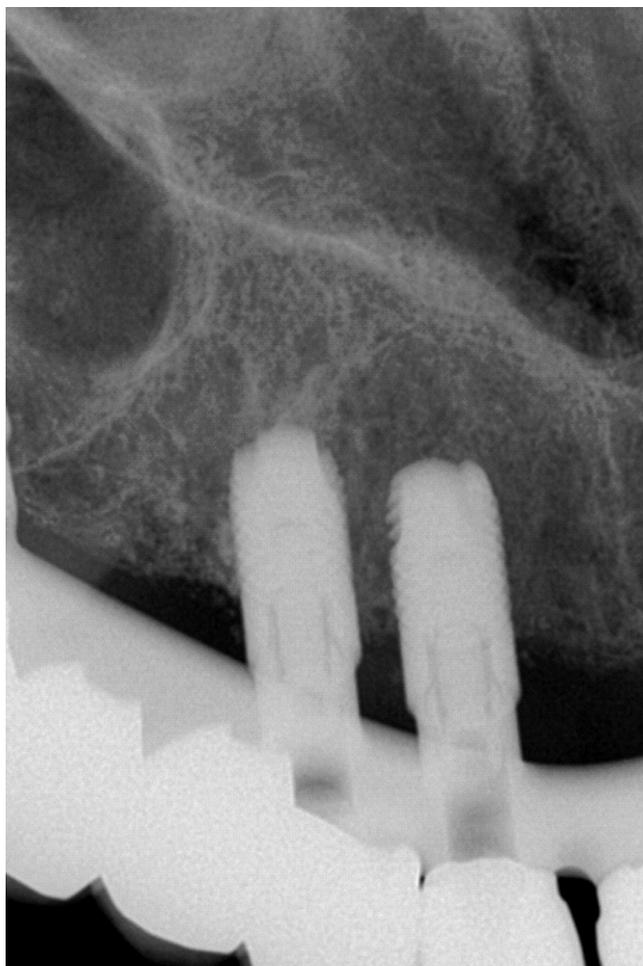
Periapical radiograph showing significant bone loss around affected implant as well as adjacent implant. Implants placed 10 years earlier.
